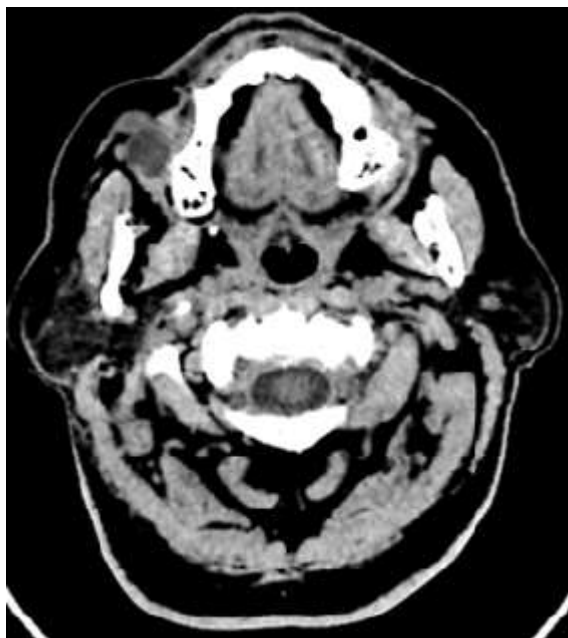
2). CT with contrast shows two cystic lesions in the right buccal mucosa measuring mm with no significant edema and inflammation or bone invasion.
